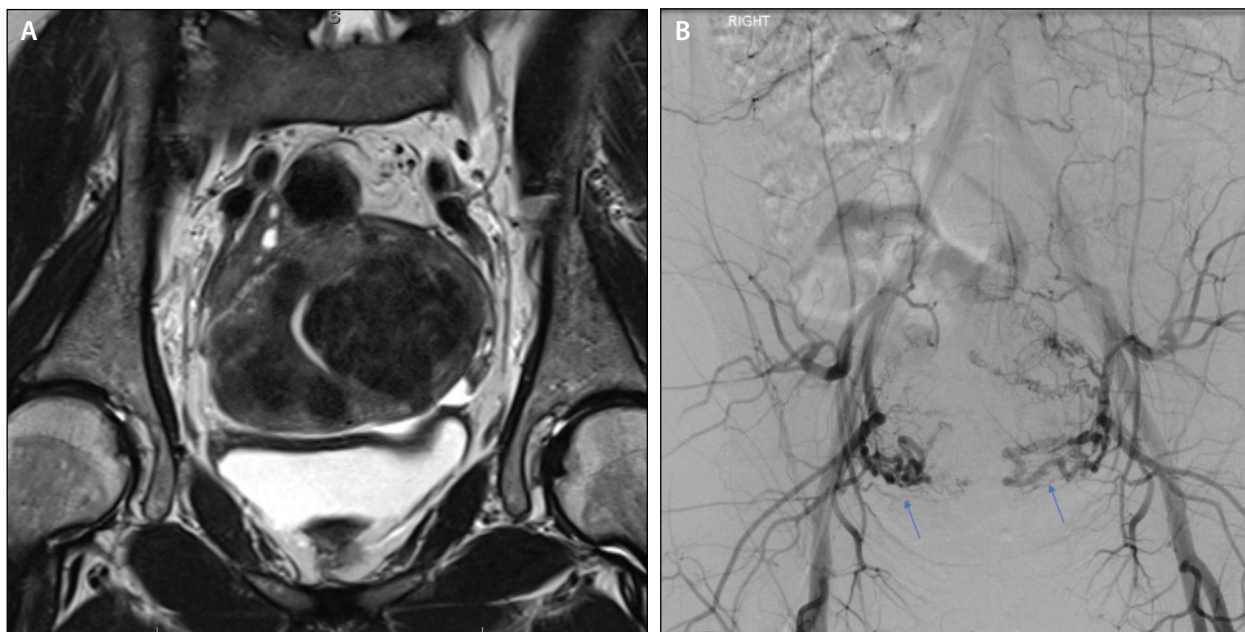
Coronal T2-weighted pelvic MRI (A) showing multiple intramural uterine fibroids and subsequent pelvic angiogram (B) in a 40-year-old woman with history of menorrhagia and bulk symptoms. The angiogram demonstrates bilateral uterine artery hypertrophy (arrows) with a hypervascular uterus.
